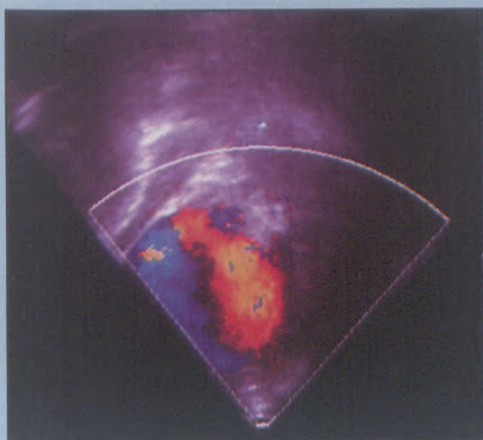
Duplex Doppler and colour Doppler ultrasound demonstrating extensive blood flow within the lesion
